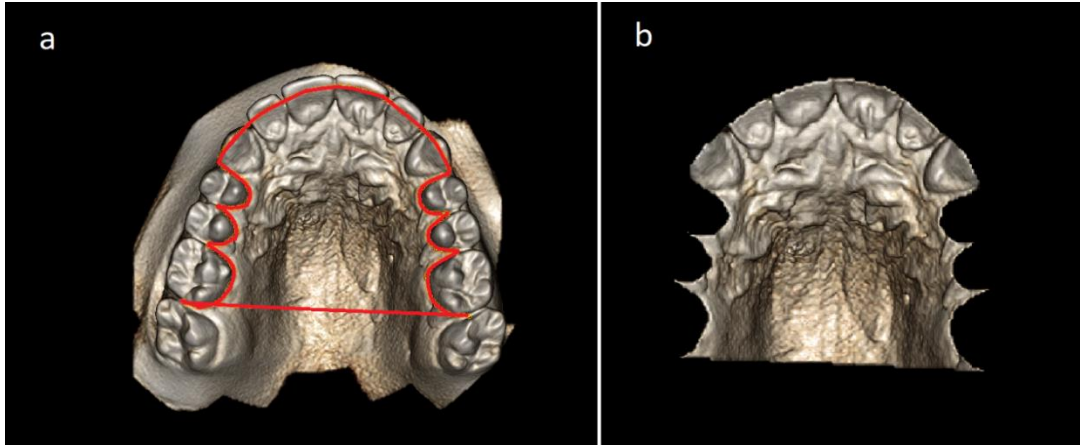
Processing CBCT Images to measure Palatal Volume
